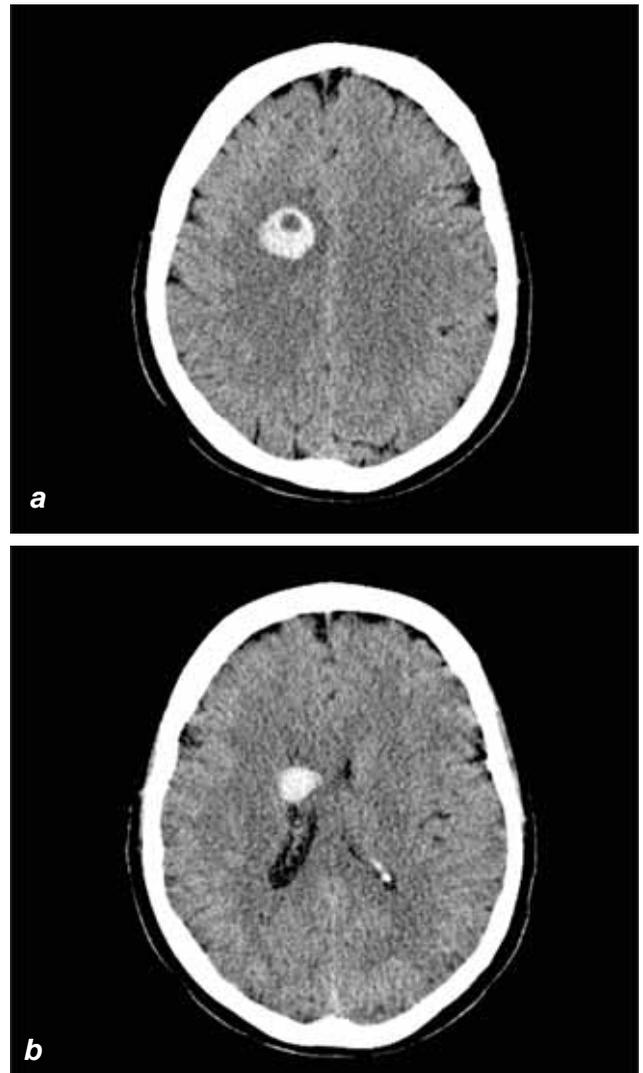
a, b Native CT scan of the brain shows right frontal hyperdense lesion with hypodense center (bull's eye sign). The lesion is well demarcated, with slight perilesional edema and mass effect on neighbouring structures.
